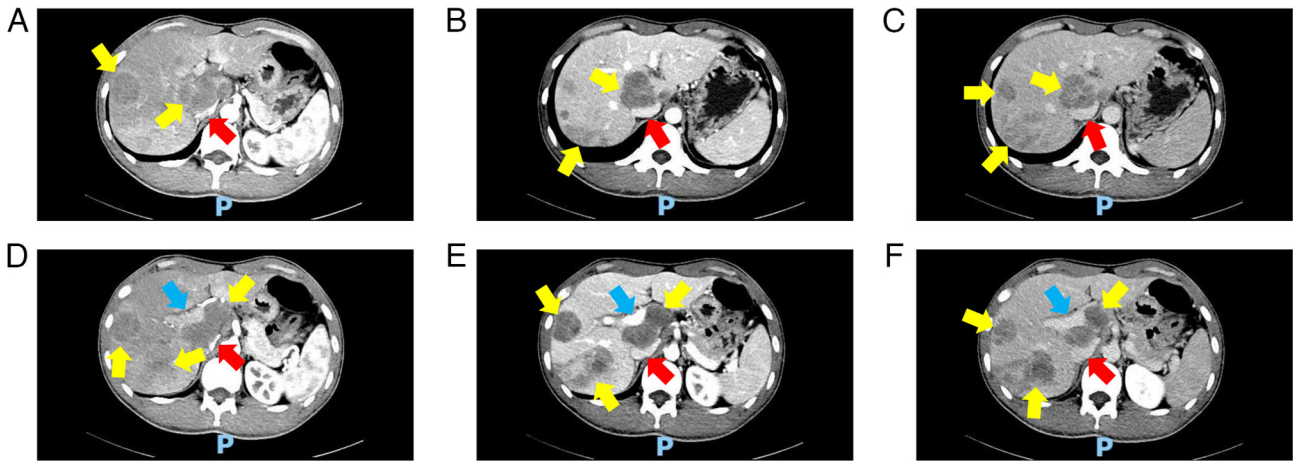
Abdominal CT scan (November 2024). Multiple metastatic lesions (yellow arrows) are present throughout the liver. (A) Arterial phase CT demonstrating the metastatic lesions (yellow arrows) compressing the inferior vena cava (red arrow). (B) Venous phase CT showing the metastatic lesions (yellow arrows) compressing the inferior vena cava (red arrow). (C) Delayed phase CT revealing the metastatic lesions (yellow arrows) compressing the inferior vena cava (red arrow). (D) Arterial phase CT showing the metastatic mass (yellow arrows) compressing both the portal vein (blue arrow) and inferior vena cava (red arrow). (E) Venous phase CT demonstrating the metastatic mass (yellow arrows) compressing both the portal vein (blue arrow) and inferior vena cava (red arrow). (F) Delayed phase CT showing persistent the metastatic mass (yellow arrows) compressing both the portal vein (blue arrow) and inferior vena cava (red arrow). P, posterior.
